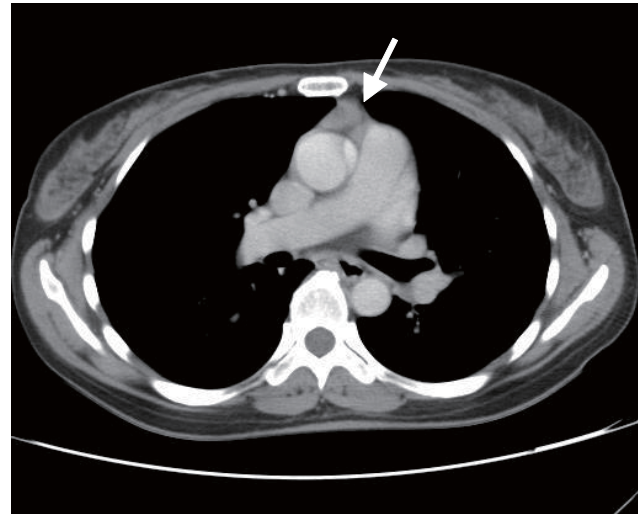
A thymic tumor on chest computed tomography. There is a lobulated nodule with enhancement with a size of 1.43 x 1.71 cm and central low density at the anterior mediastinum.
